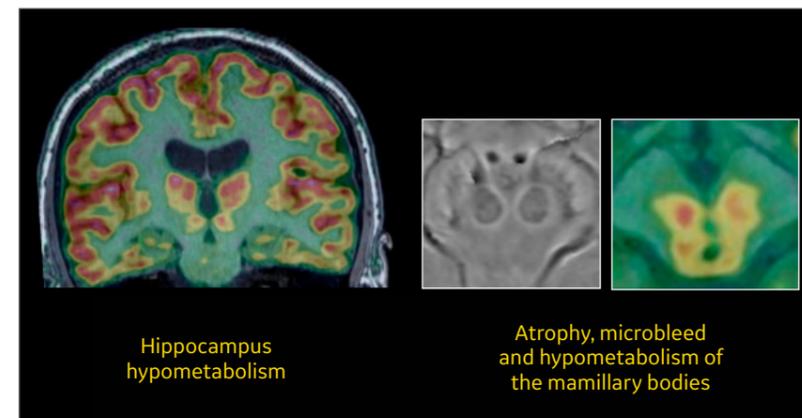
PET images acquired with a GE digital detector available in both SIGNA™ PET/MR and Discovery™ MI PET/CT systems.
